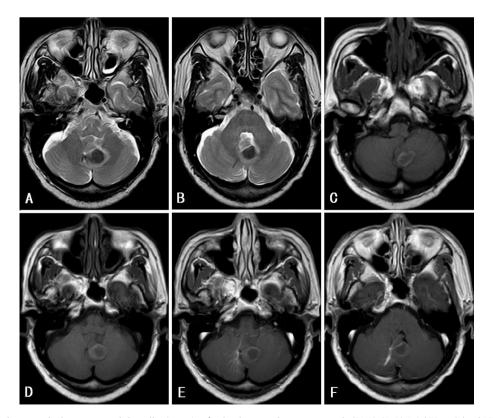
Close relationship between the hematoma and the collecting vein of a developmental venous anomaly (DVA). (A, B) Axial T2-weighted MRI showing a hypointense lesion indicative of a hematoma and several linear flow voids adjacent to the hematoma. (C, D) Axial T1-weighted MRI showing the isointense hematoma, with flow void signal faintly visible. (E, F) Axial T1-weighted MRI with contrast enhancement clearly showing the caput-medusae-like appearance of the DVA. The hematoma is located within the territory of the venous drainage of the collecting vein.
